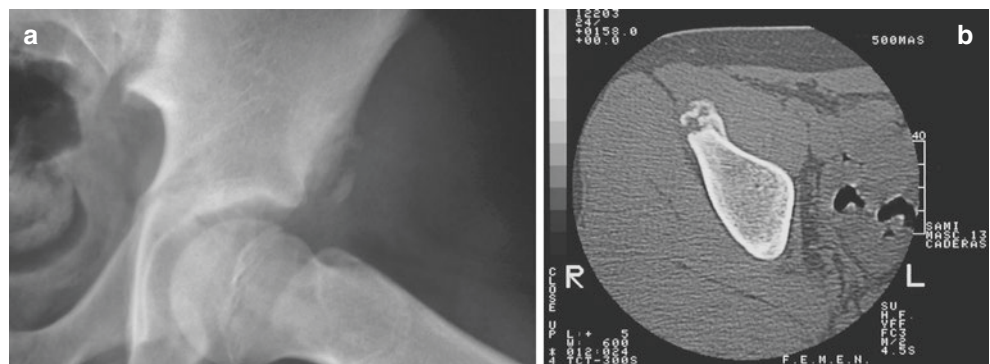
Avulsion injury. Roentgenogram (a) and CT scan (b) showing a cortical avulsion in the iliac spine at the insertion of the rectus femoris
